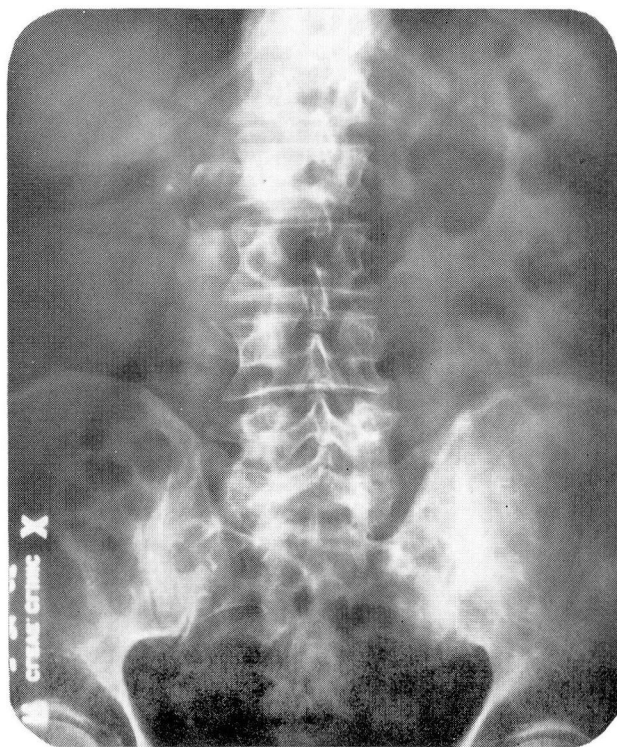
Roentgenogram showing calcification in the head of the pancreas.
